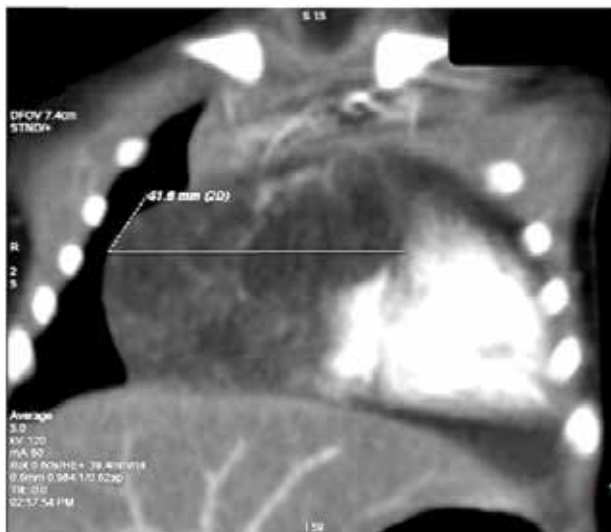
CT scan chest showing the anterior mediastinal mass.
